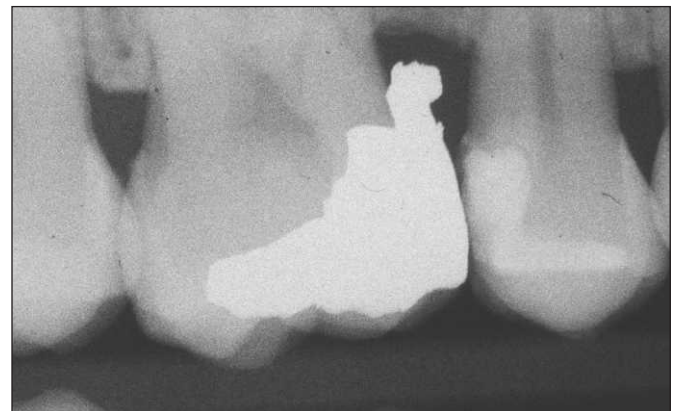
Bitewing radiograph of an MO amalgam restoration on a maxillary molar. Excessive overhang is the result of incorrect wedging. Destruction to the periodontium is evident.
